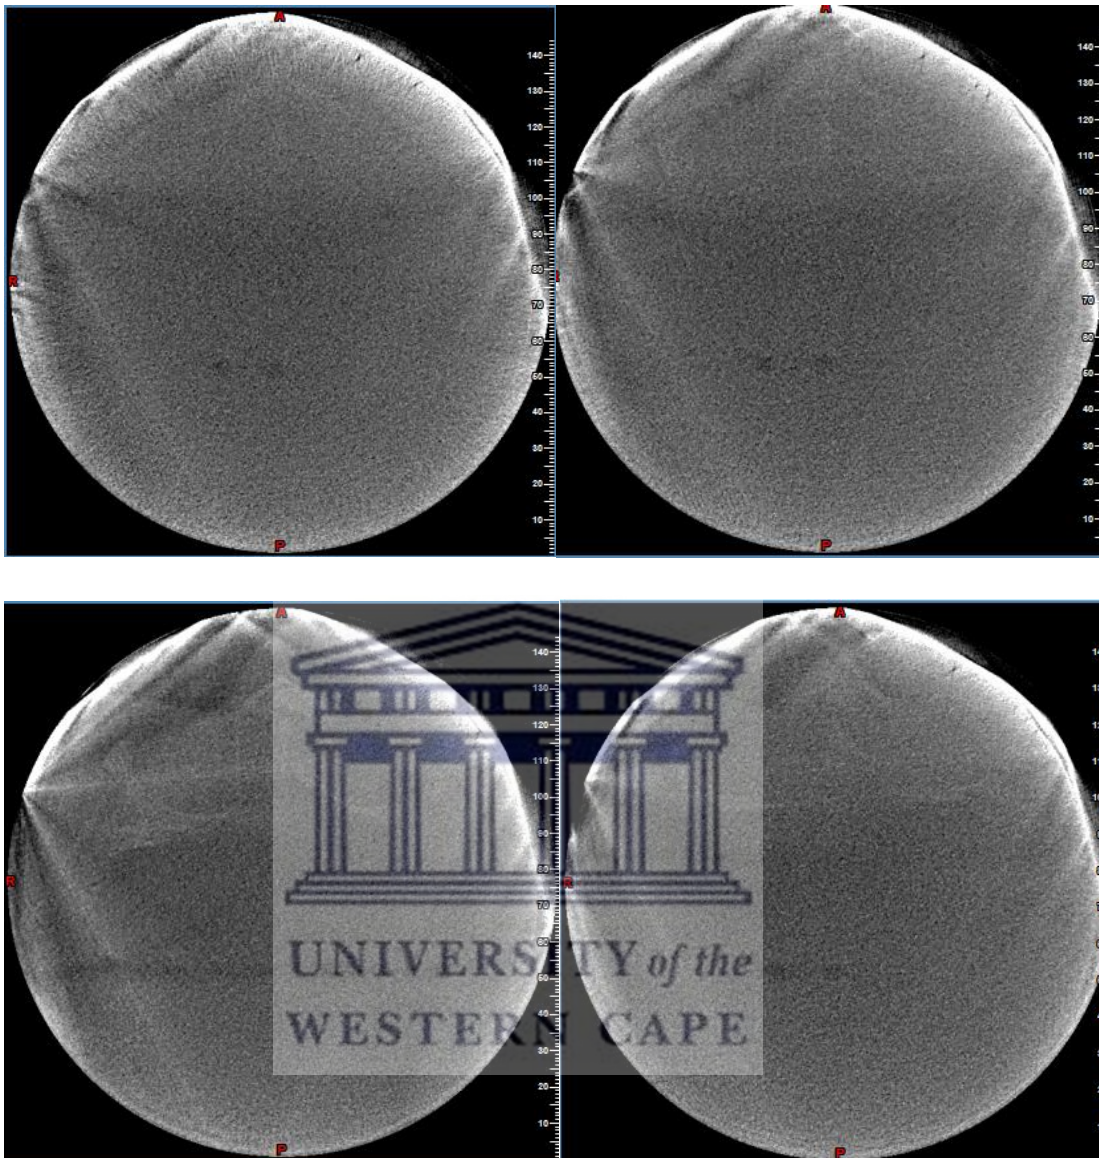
Axial slice (top left), coronal slice (top right), sagittal slice (bottom left), and 3D view (bottom right), reconstructed from CBCT volume with the attached modified shield (NewTom® 5GXL, FOV 15 × 12 cm, regular scan, and standard dose).
